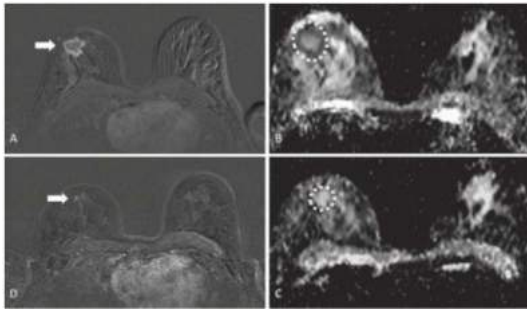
• MRI showing response to chemotherapy before treatment (A) and after treatment (B).
